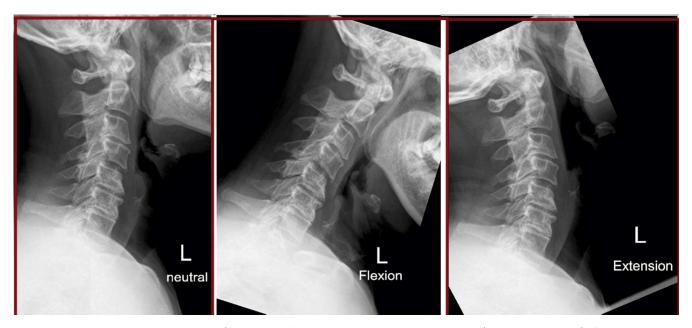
lateral radiograph showing spondylosis (degenerative disc space narrowing and osteophytic spurring) in the cervical spine. On flexion, there is an anterolisthesis of C4 with respect to C5 secondary to degenerative facet joints; this likely contributes to canal stenosis at C4/5. (Case and caption courtesy of Dr Yi-Jin Kuok, Radiopaedia.org, rID: 18348)
